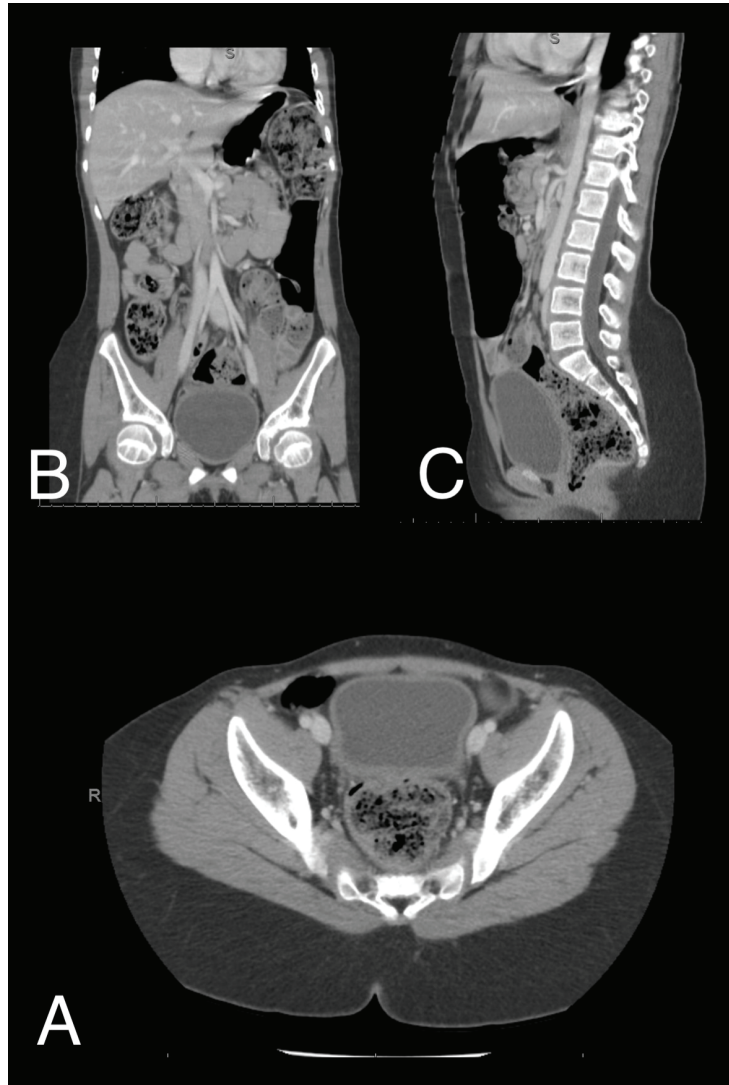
A. Cross Sectional, B. Coronal, and C. Sagittal Sections, CT scan of the abdomen, showing absence of ovaries and uterus.*
